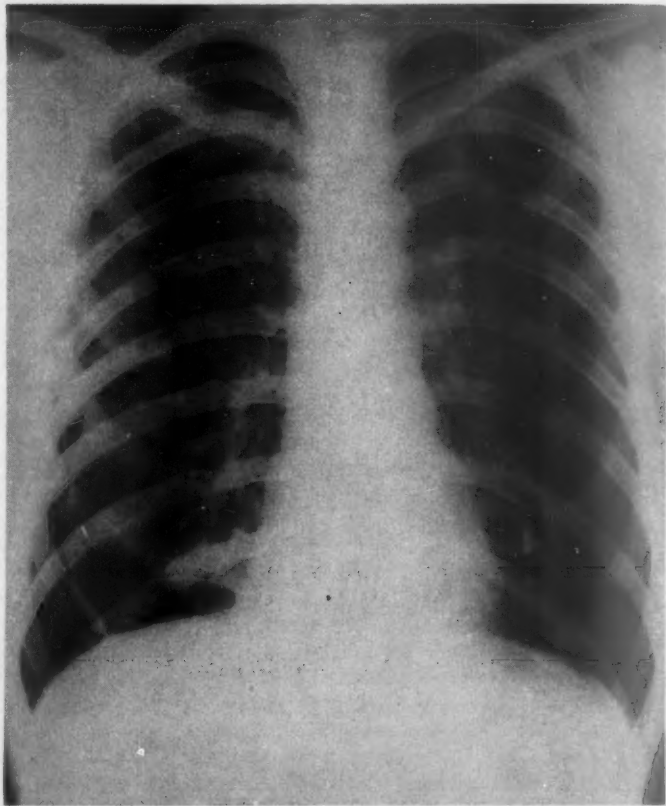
Chest x-ray at time of admission, revealing nodular densities, cystic lesion in left upper lung, and partial right pneumothorax.
